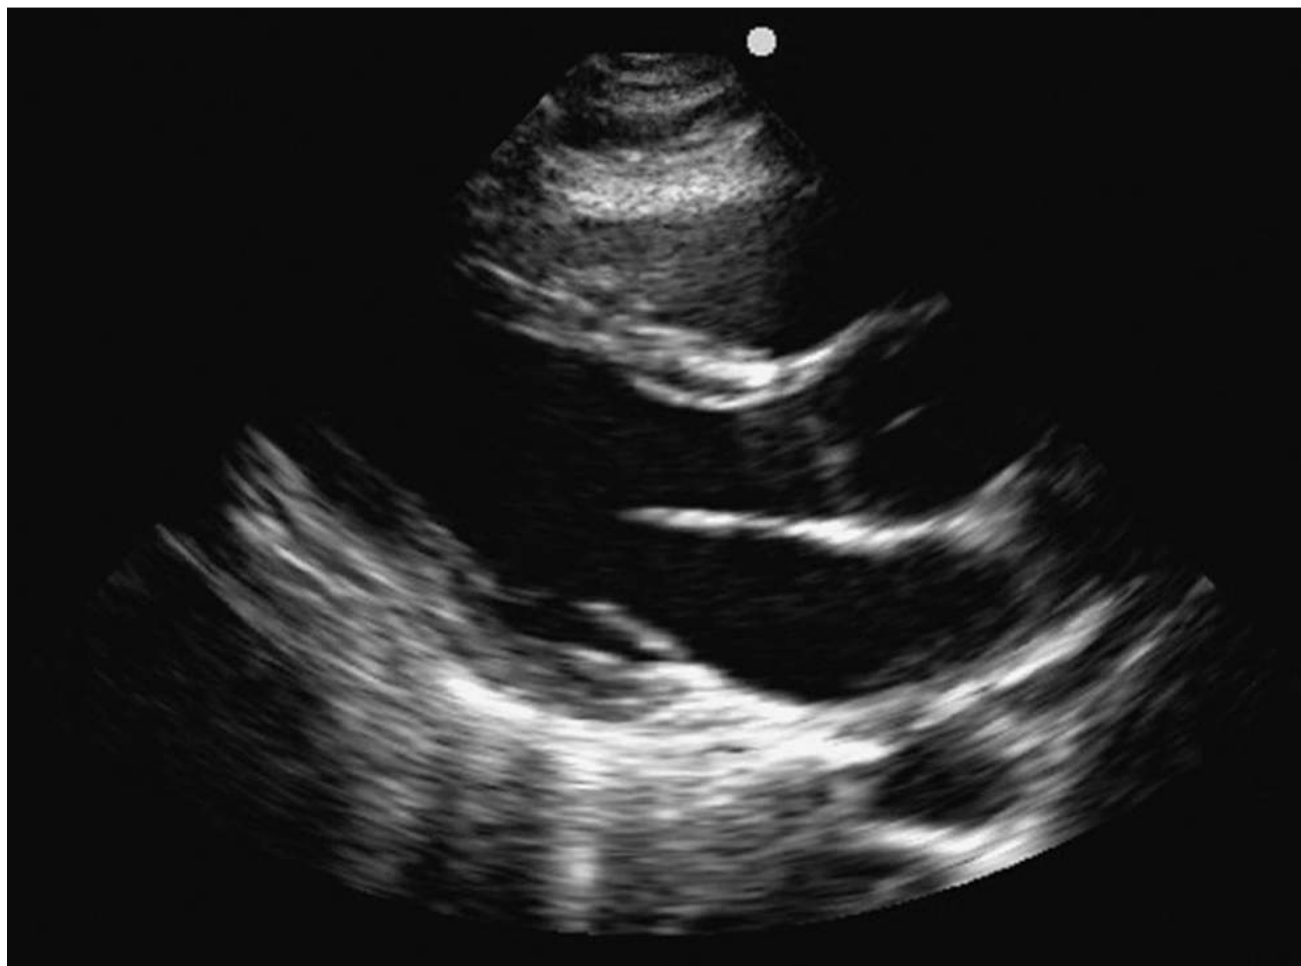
Parasternal long-axis view of a normal heart. The right ventricle (RV) is the most anterior chamber and the right atrium is not in view. A true long-axis view of the left ventricle displays both the aortic and mitral valves simultaneously. The mitral valve is open; the heart is in mid-diastole. Note the descending aorta posterior to the left ventricle. Just anterior to the aorta, the bright echogenic pericardium wraps around the heart in a clockwise fashion.
